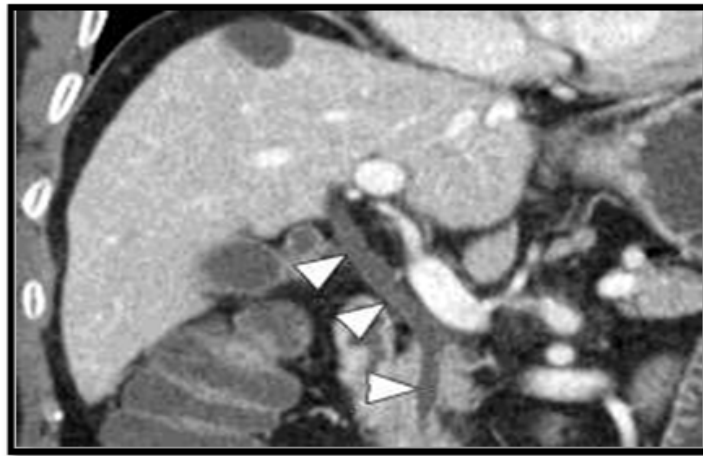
shows coronal intravenous contrast-enhanced reformatted image from CT data shows the CBD and CHD (arrowheads), which are normal caliber and have an imperceptible wall. The IBDs are barely visible (Radiopeadia, 2016).
